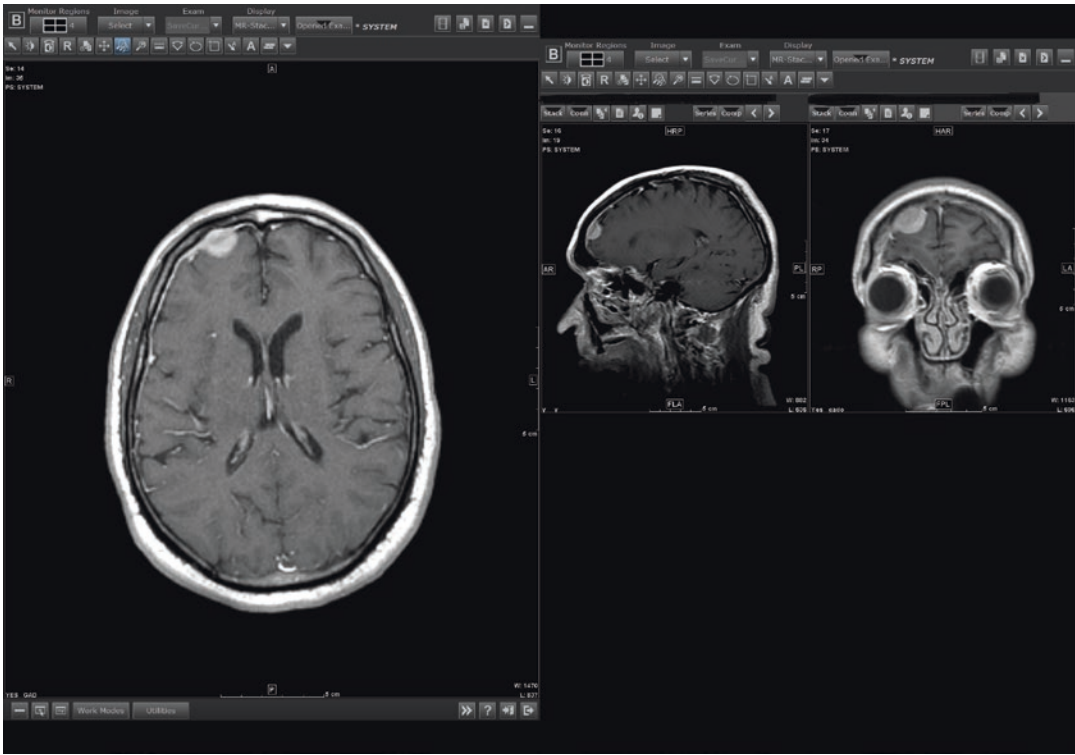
Rosai–Dorfman disease of the brain dura: axial, coronal, and sagittal gadolinium-enhanced T1-weighted MRI demonstrates an enhancing dural-based
